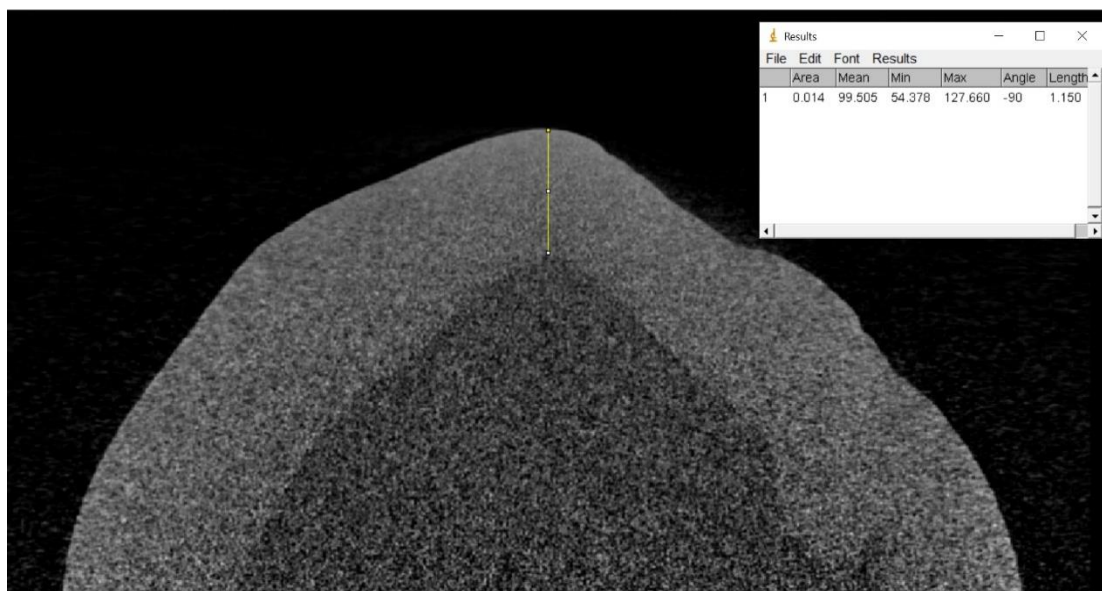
Example of baseline measurement of a μ -CT coronal image using ImageJ 1.48 software.
